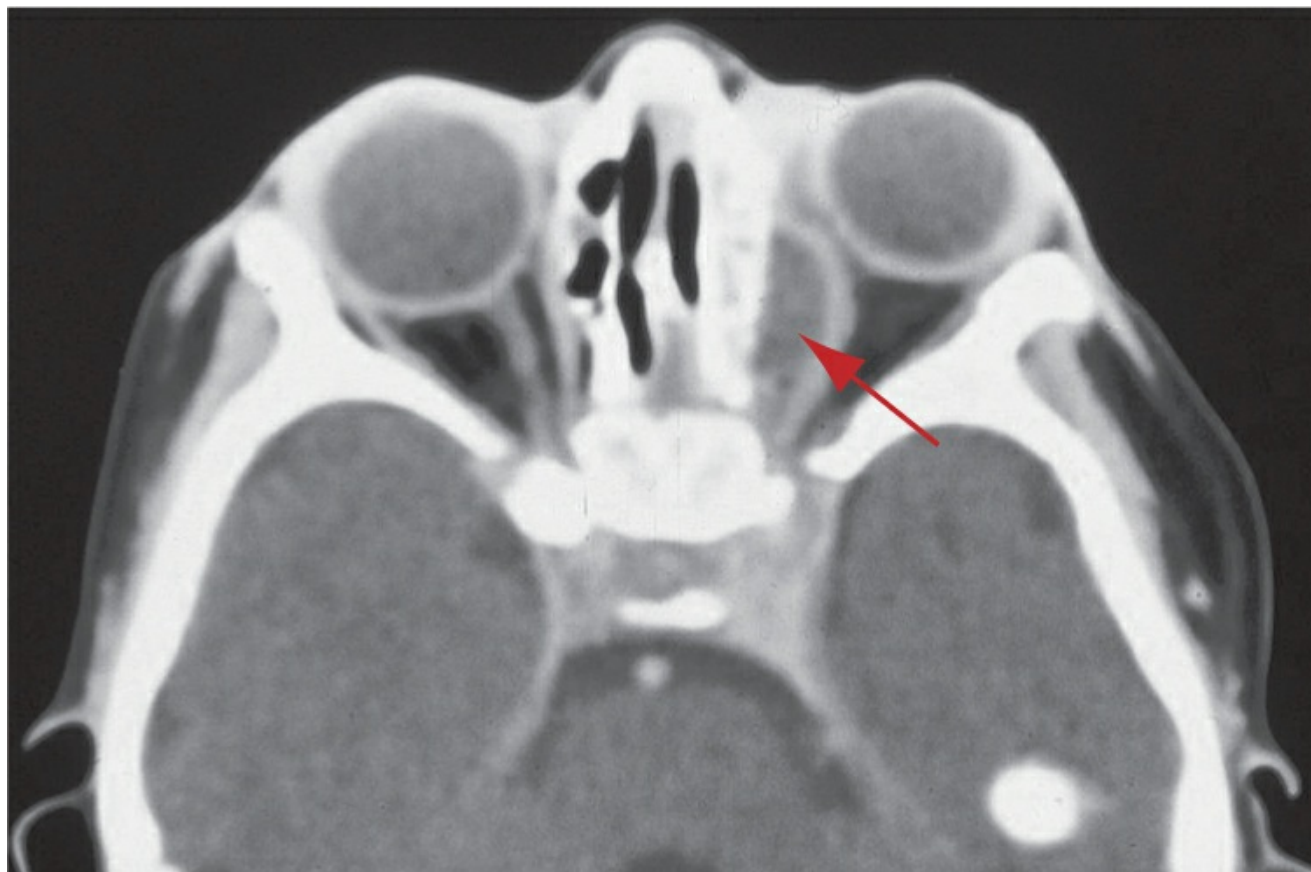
Axial computed tomography (CT) image showing a medial subperiosteal abscess (arrow) of the left orbit associated with ethmoid sinusitis. (Courtesy of Jane Edmond, MD.)
